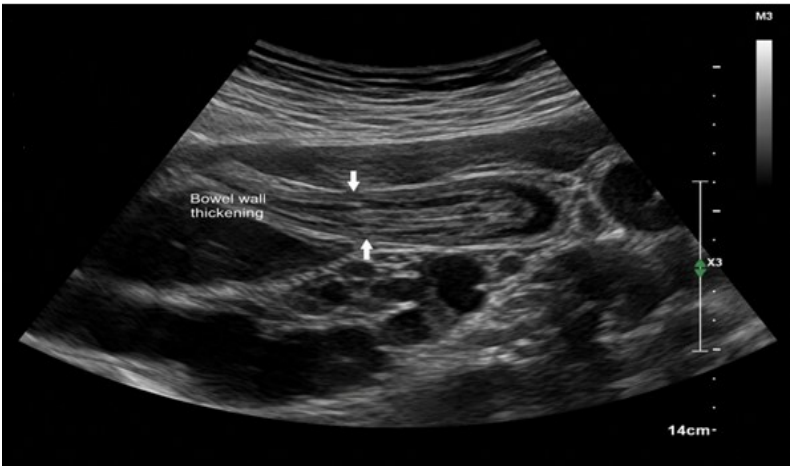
Grayscale ultrasound demonstrating bowel wall thickening.
